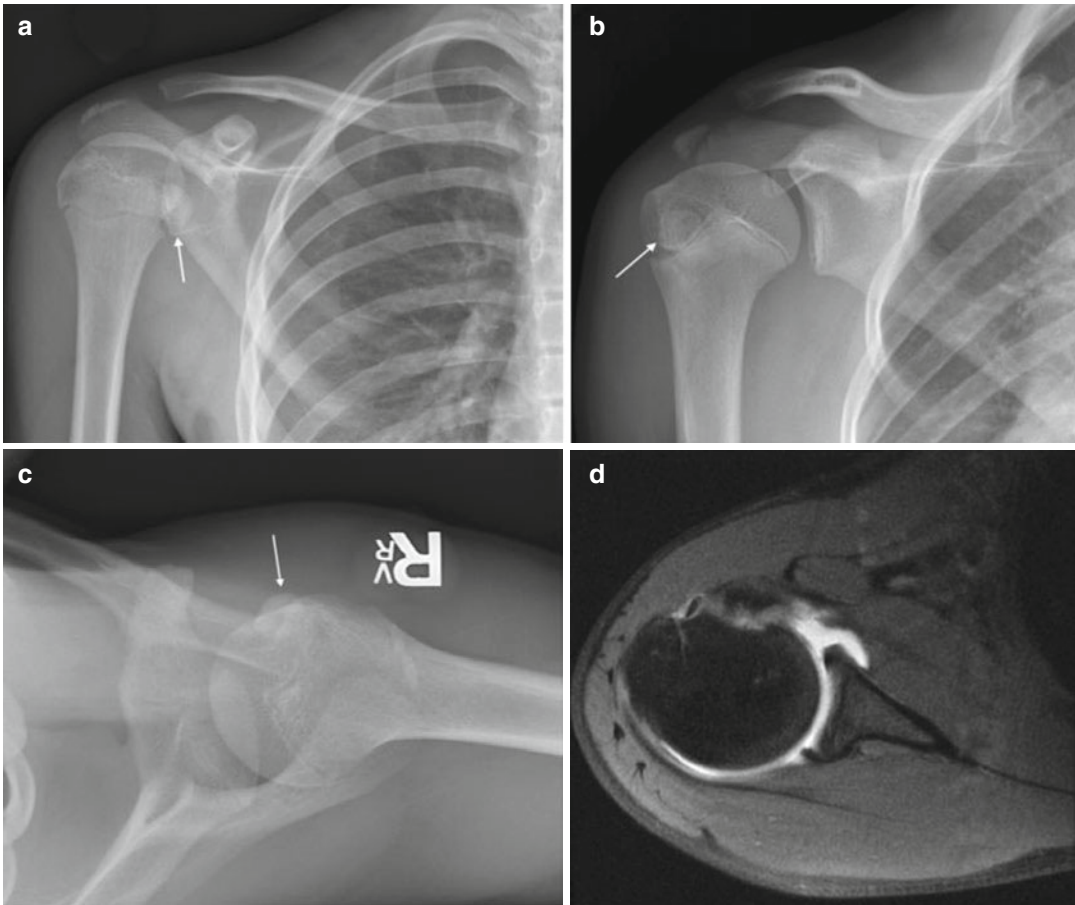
A 12-year-old male sustained an injury to the right shoulder while playing baseball. The lesser tuberosity avulsion (white arrow) is seen on (a) AP radiograph with internal rotation (b) Grashey view and (c) axillary
